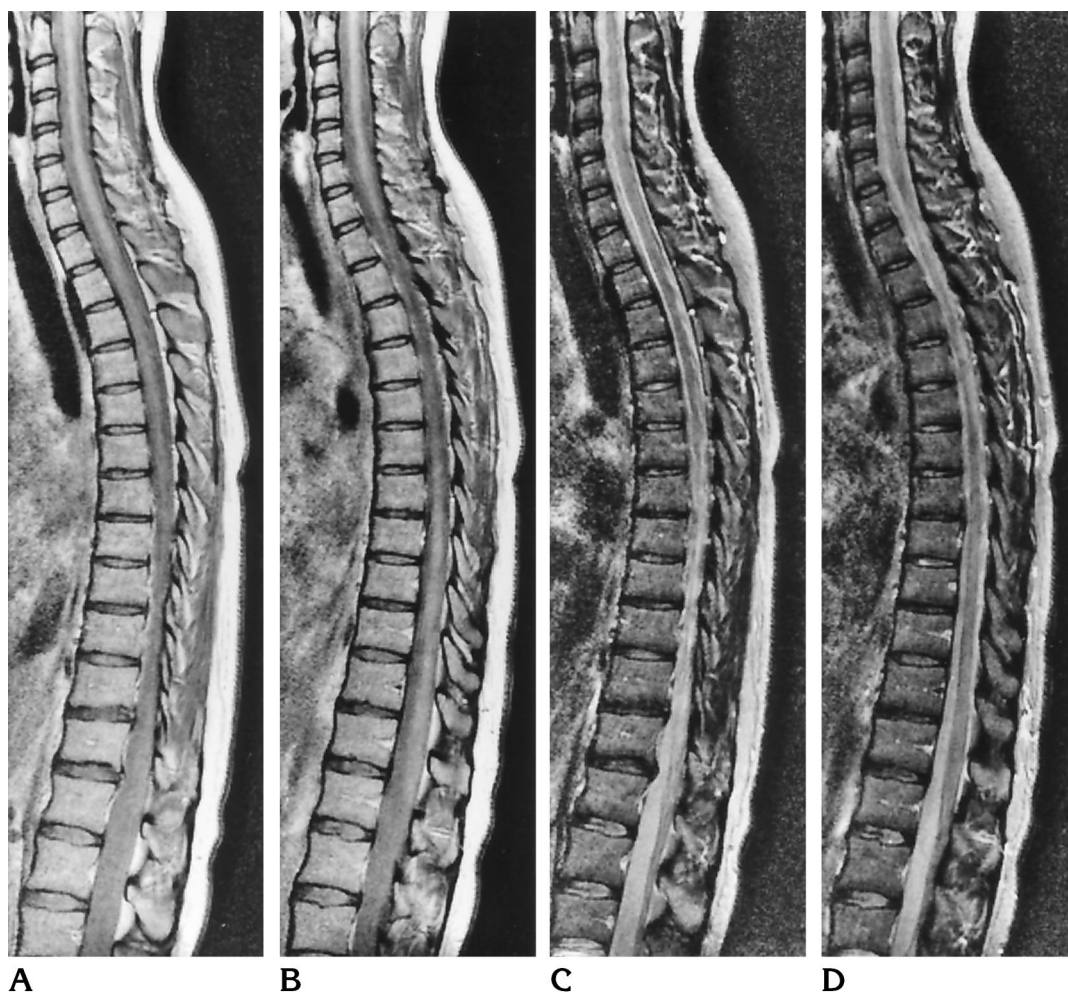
Type III MR finding. Sagittal proton density-weighted (A, B) and T2-weighted (C, D) MR images (2200/20,80/1) of a patient with primary progressive MS: the spinal cord shows diffuse involvement on the proton density-weighted images, whereas no focal lesions are visible on the corresponding T2-weighted images.
